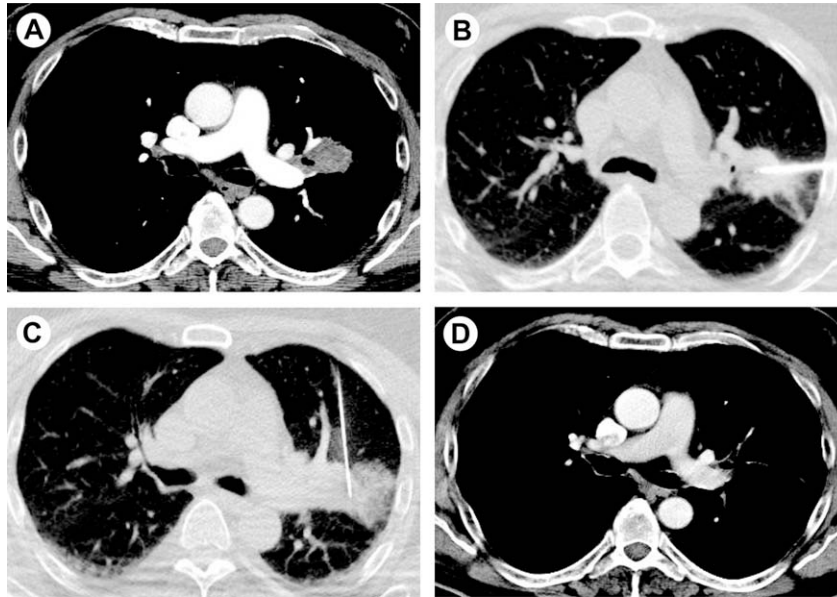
A 60-year-old man with 3.0×2.7 cm-sized mass on left upper lobe, which was confirmed pathologically as an adenocarcinoma. (A) Initial CT section of lung window shows the ill-defined mass adjacent to the left main pulmonary artery. (B–C) CT sections of lung window during PTC. Initially, cryoablation was performed by horizontally inserted cryoprobe. Another cryoprobe was then inserted vertically and remnant mass was ablated. (D) Follow-up CT at 10 months after PTC showing the disappearance of lung mass.
